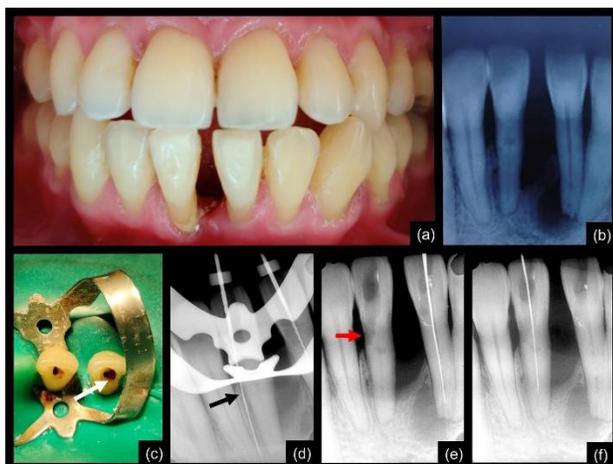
(A and B) Clinical and radiographic presentation of mandibular right and left central incisors (31,41). (C and D) Clinical picture and periapical radiograph showing the presence of cervical perforation (arrows representing the location of perforation). (E and F) Periapical radiograph displaying working length estimation of 31 and 41.
